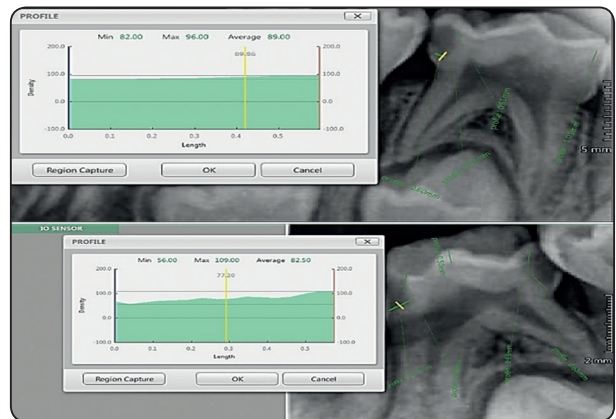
Pre-operative radiographs of both sides
